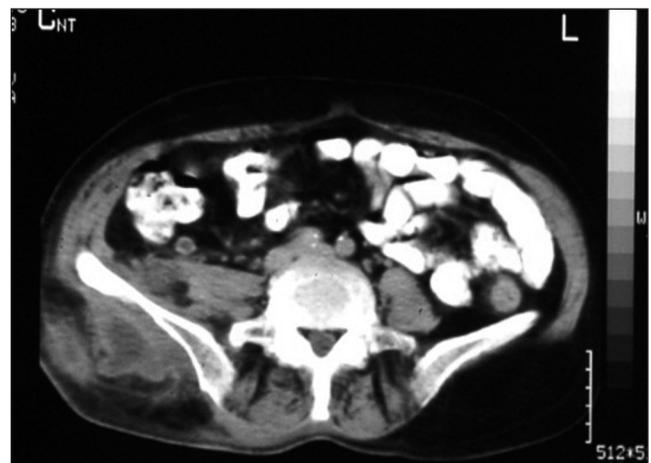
CT scan demonstrating the retroperitoneal pseudomyxoma.
